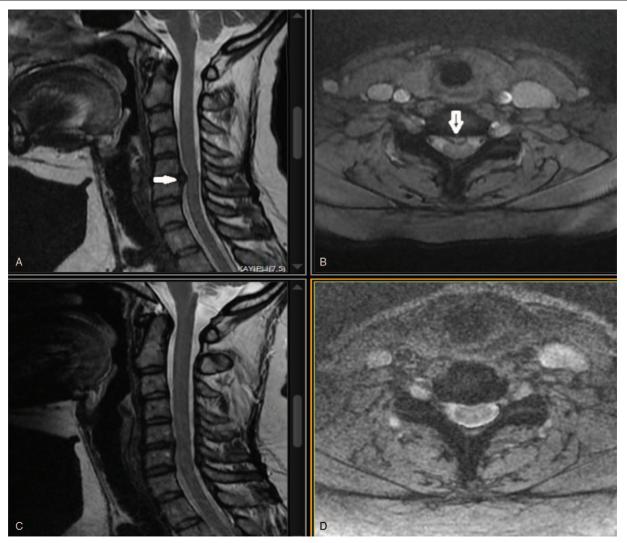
Of case 7, (A, B) Sequestered CDH on sagittal and axial spinal cervical MRI on admission (white arrow). (C, D) Resorption image of the disc on control spinal cervical MRI. CDH = cervical disc herniation.
